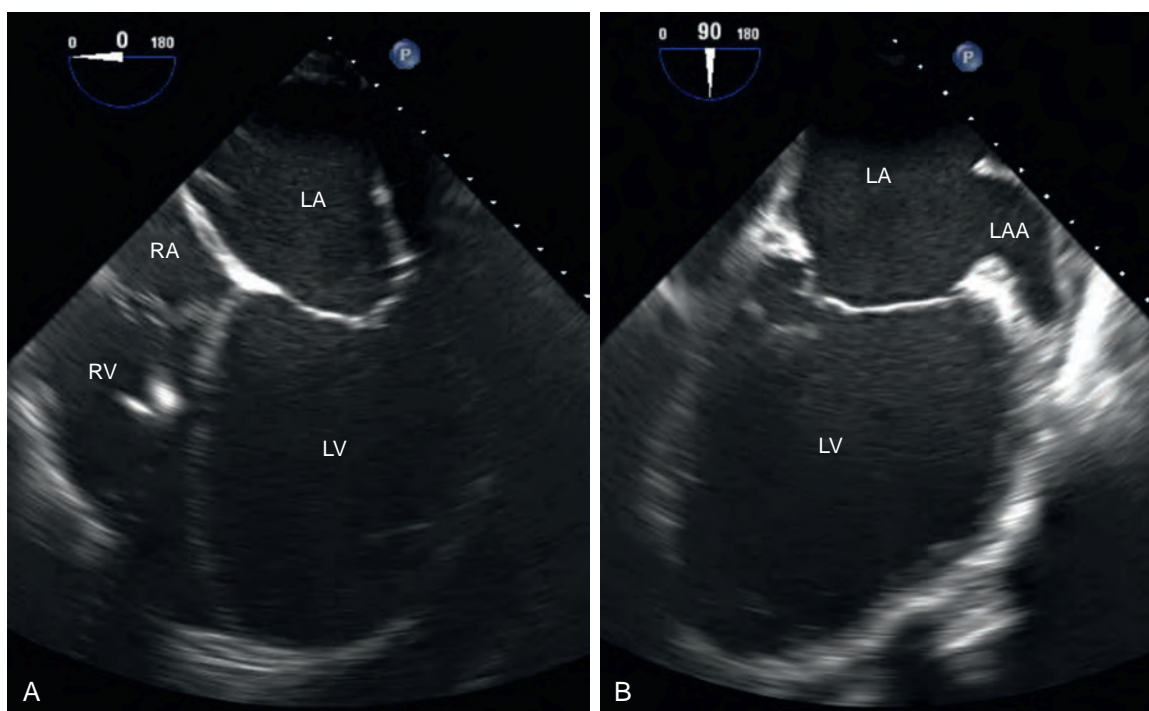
Transesophageal echocardiographic still frames in the (A) midesophageal four-chamber view and (B) midesophageal two-chamber view of a patient with postviral myocarditis dilated cardiomyopathy. Note the large left ventricle (LV) with apical tenting of the mitral valve. LA, Left atrium; LAA, left atrial appendage; RA, right atrium; RV, right ventricle.
